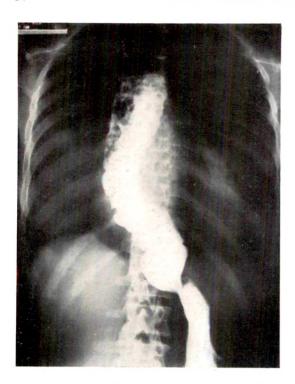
Case III. At the first roentgenologic examination the usual findings of achalasia of the cardia were revealed. At this time the esophagus was filled with a large amount of fluid and retained food. This accounts for the mottled and irregular appearance of the esophageal shadow.
